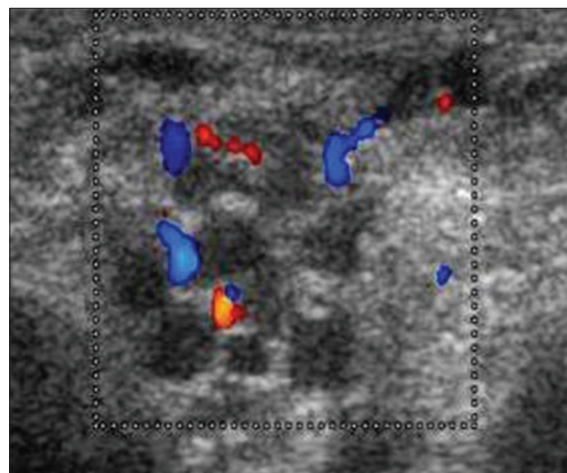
Ultrasound scrotal Doppler of left varicocele Grade III
